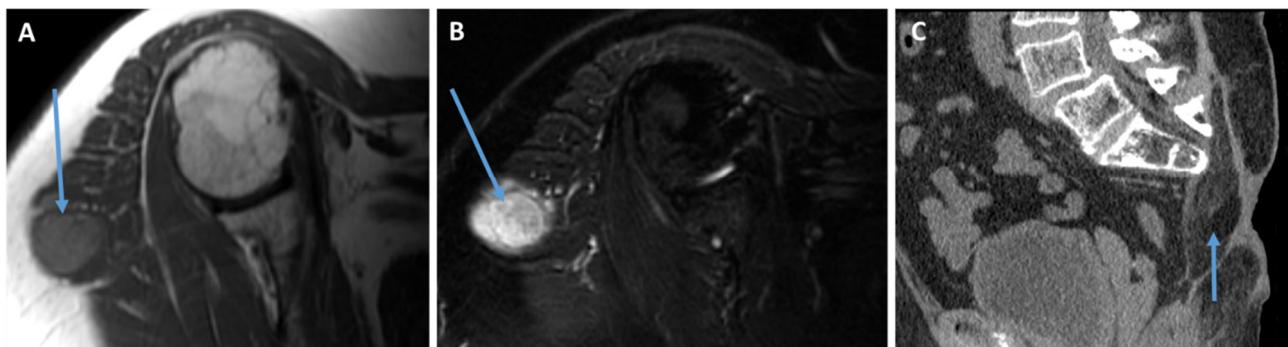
A–C: Chordoma metastasis to soft tissue. 69-year-old female with history of sacral chordoma status post sacroccygectomy (C) who presented with a mass in the right shoulder region. MRI showed a lobulated T2 hyperintense, T1 hyperintense mass embedded in the posterior deltoid which was proven to be a chordoma metastasis.
